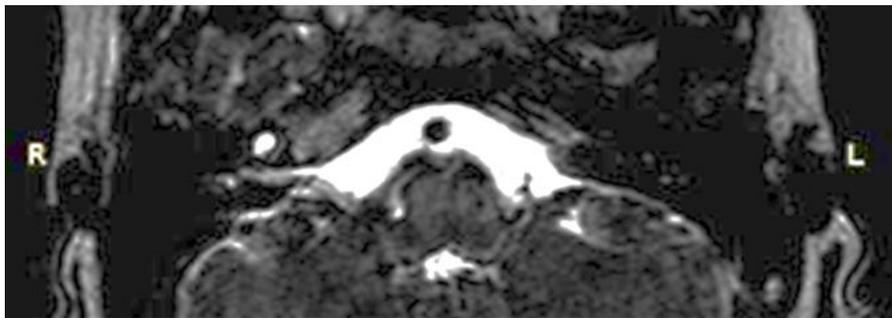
Preoperative MRI - very thin nerve fibers corresponding to the single cavity of the inner ear on the right side (branch of the vestibular right nerve)
